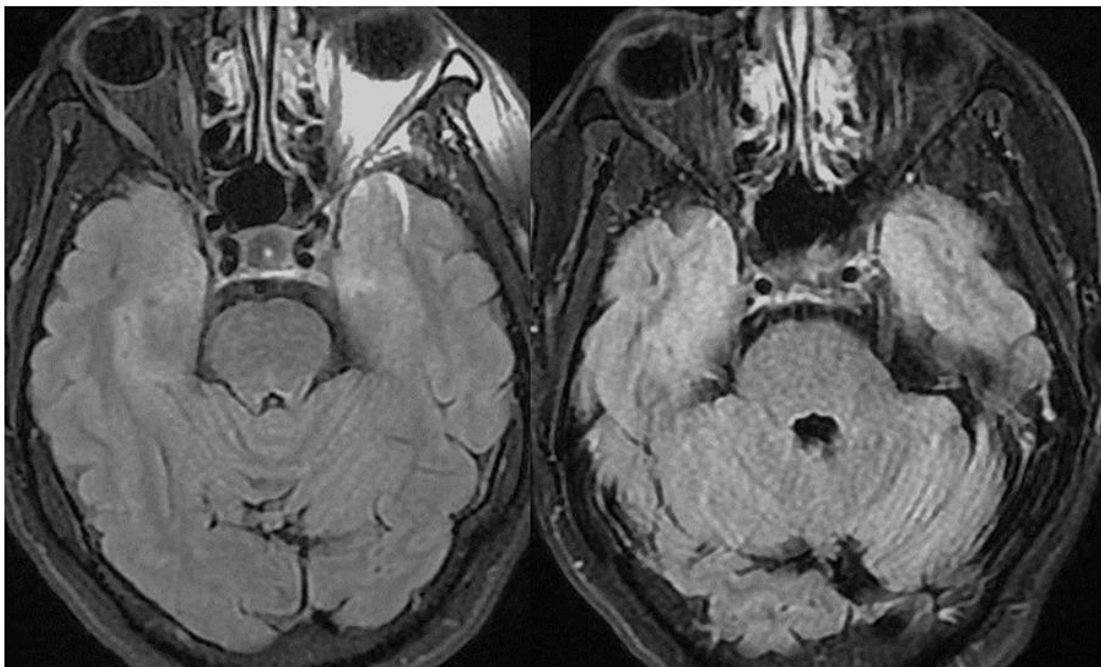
MRI FLAIR sequence showed diffuse cortical swelling in the right and the left temporal regions.
